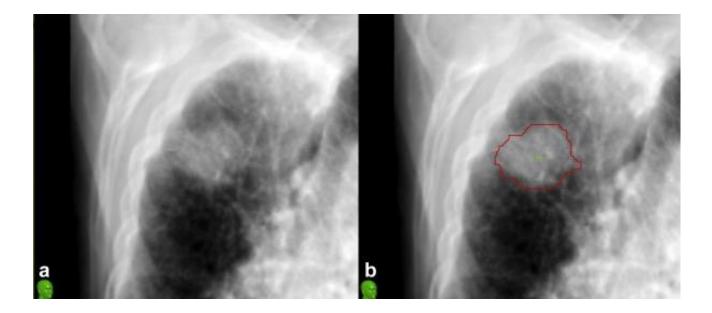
Digitally reconstructed radiograph in the radiotherapy treatment planning system showing a lung tumor, without contour (a) and with contour (b), which was suitable for the Xsight Lung Tracking System. The Xsight system does not require fiducial markers for tumor tracking. Tumors must be of sufficient density for visualization by the system and must measure at least 1.5 cm in diameter.
